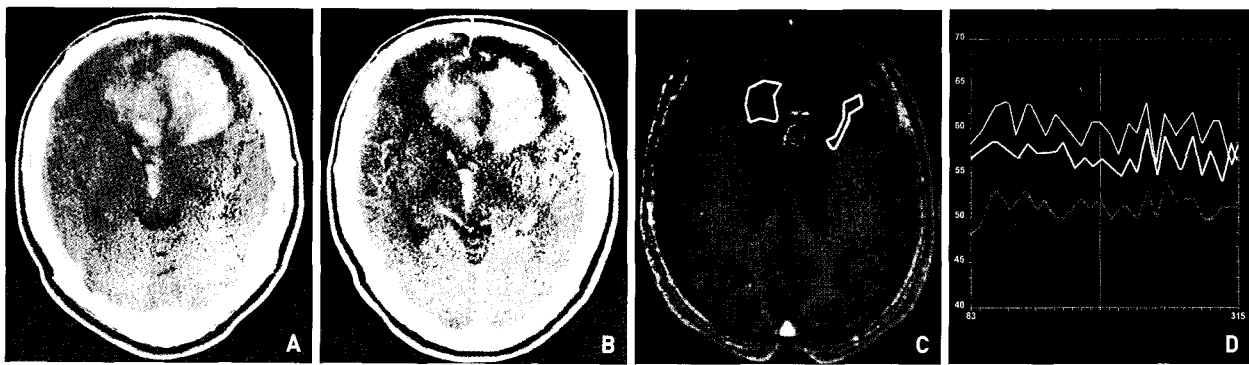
A 57-year-old male patient with anaplastic astrocytoma with tumor bleeding (case 5). A : Pre-contrast image of computed tomography of the brain. B : After administration of contrast materials. C : Magnetic resonance images were taken 4 months after the operation, and dynamic scan was taken from the surrounding areas (yellow, red and white). D : “N pattern” is noted in all areas.
